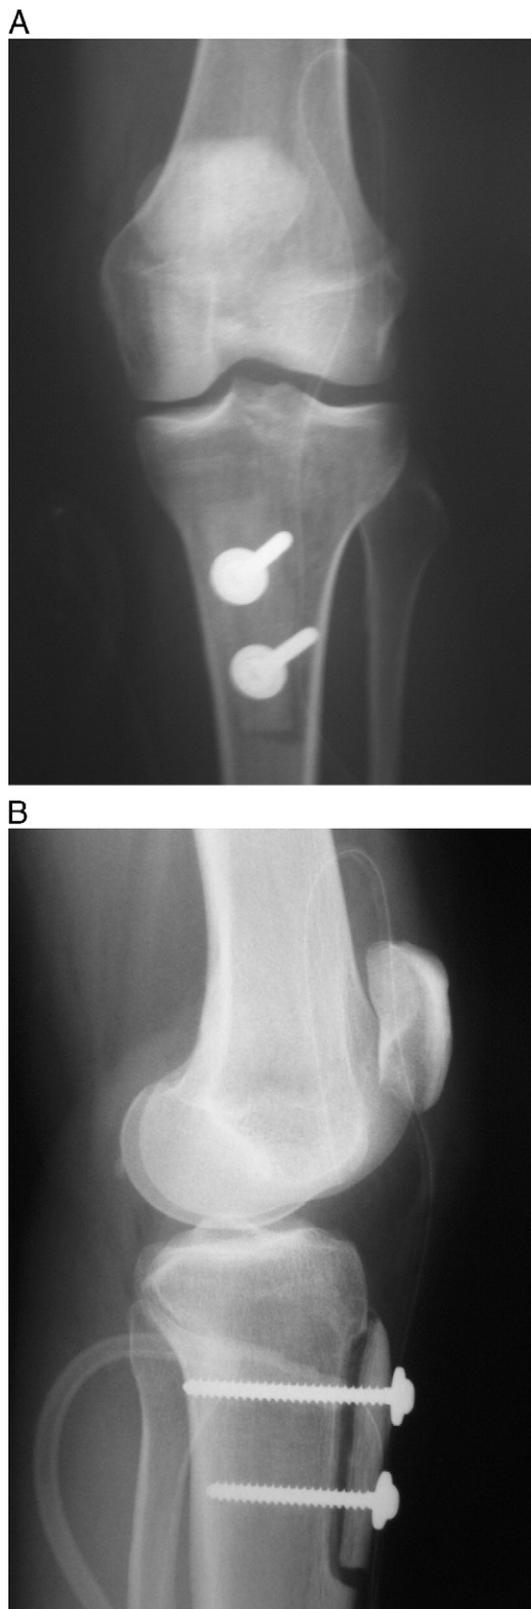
(A) Anteroposterior radiograph immediately post Elmslie–Trillat procedure. (B) Lateral radiograph immediately post Elmslie–Trillat procedure.
